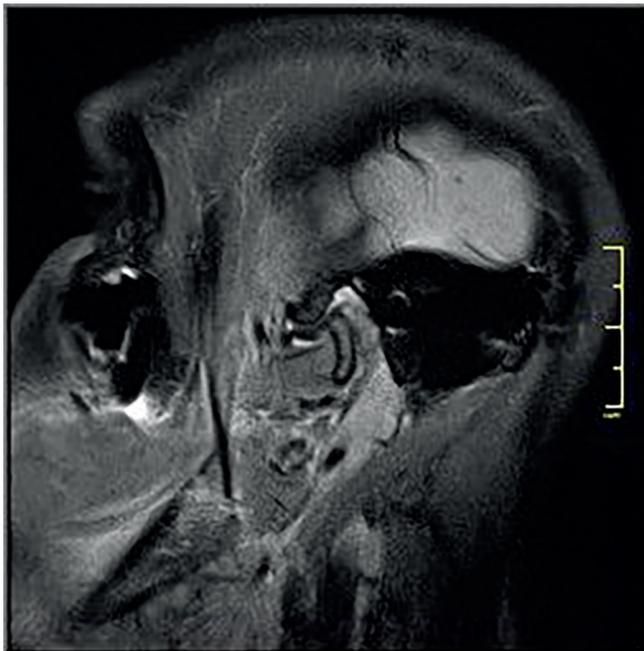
MRI signs of hematoma, deformity and penetration of the capsule of the TMJ. Limited mouth opening ranging from 30 to 38 mm was found in 11 (45,83 %) patients. Lower jaw deviation was observed in 18 (75%) patients. All patients had articulatory noises - clicking, and 11 (45,83 %) had blocked movement of the joint head. Orthopantomograms or CT revealed no signs on mandibular fractures. Ultrasound and MRI revealed signs of unabsorbed hematoma (consequences of hemarthrosis) (Fig. 1); in 18 patients - deformity
